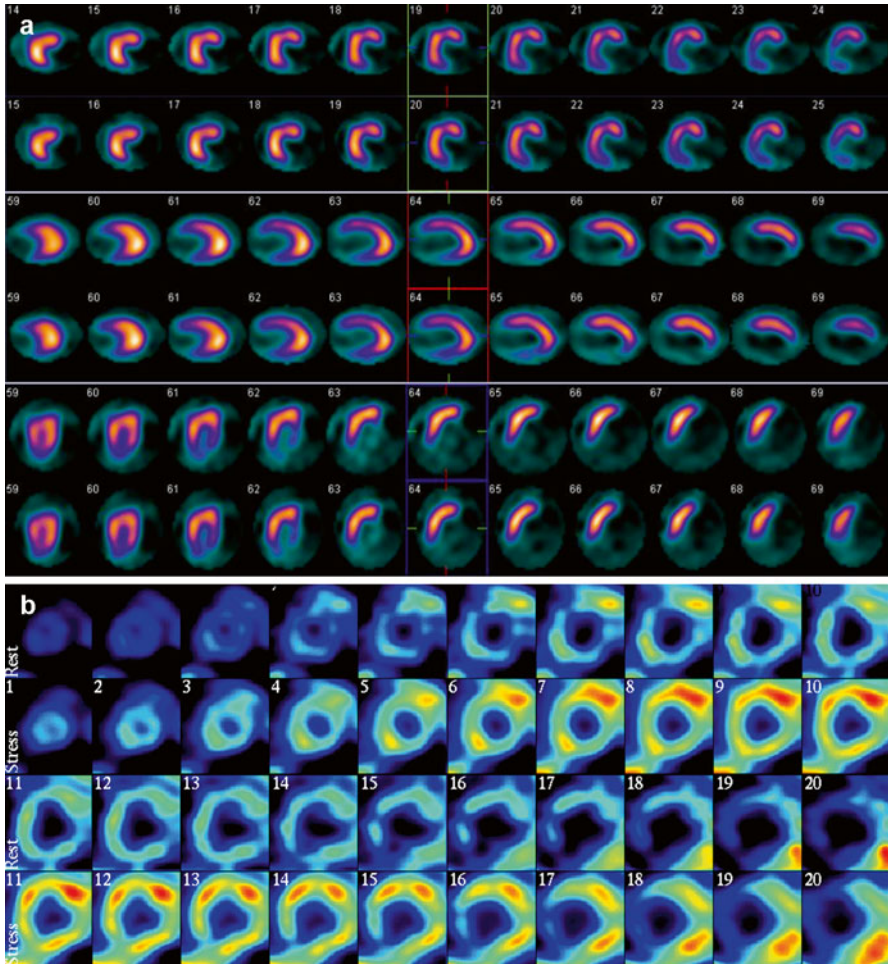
Irreversible defect in the infero-postero-lateral wall on a [^{99m}Tc]-tetrofosmin myocardial perfusion SPECT scan (a), indicating myocardial infarction. Infarction in the inferior wall and basal infero-septal region on a [^{13}N]NH $_3$ PET scan but preserved global perfusion reserve in the remaining tissue (b)
